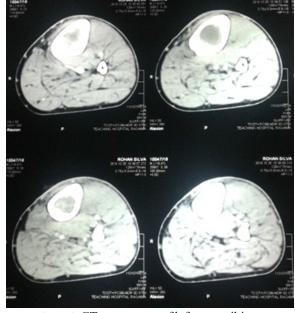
CT appearance of left upper tibia
